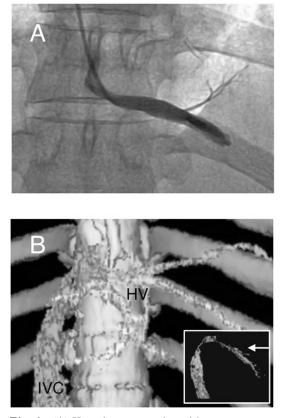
(A) Hepatic venography with anteroposterior view. The stenotic site could not clearly visualized from this study. (B) Three-dimensional CT image of hepatic vein and inferior vena cava with anteroposterior view. Image on right-lower corner is the view from right side. Arrow indicates the axis of anteroposterior view. HV, hepatic vein ; IVC, inferior vena cava.
